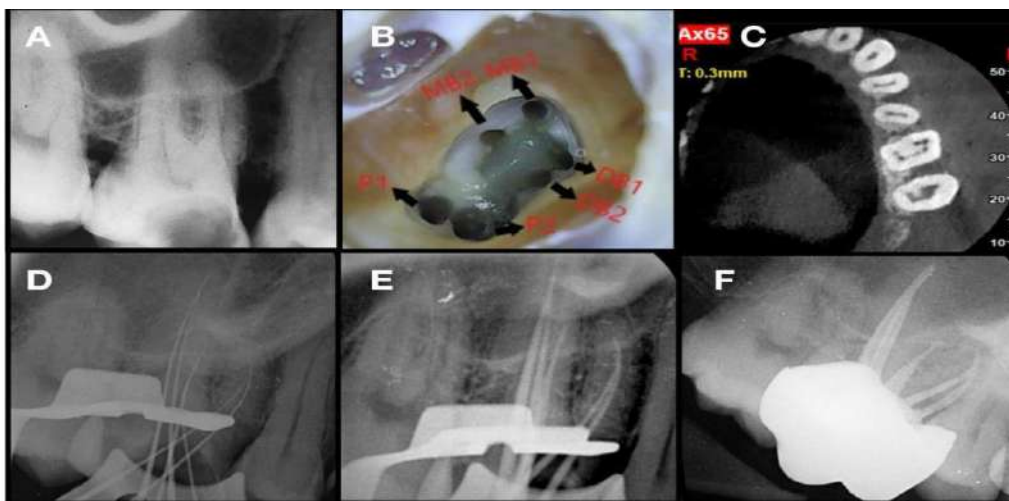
A- Preoperative radiograph; B- Access opening showing two mesiobuccal (MB1 and MB2), two palatal (PI and P2) and two distobuccal (DB1 and DB2) canal orifices; C- CBCT image ; D- Working Length radiograph; E- Master cone radiograph; F- Obturation radiograph
